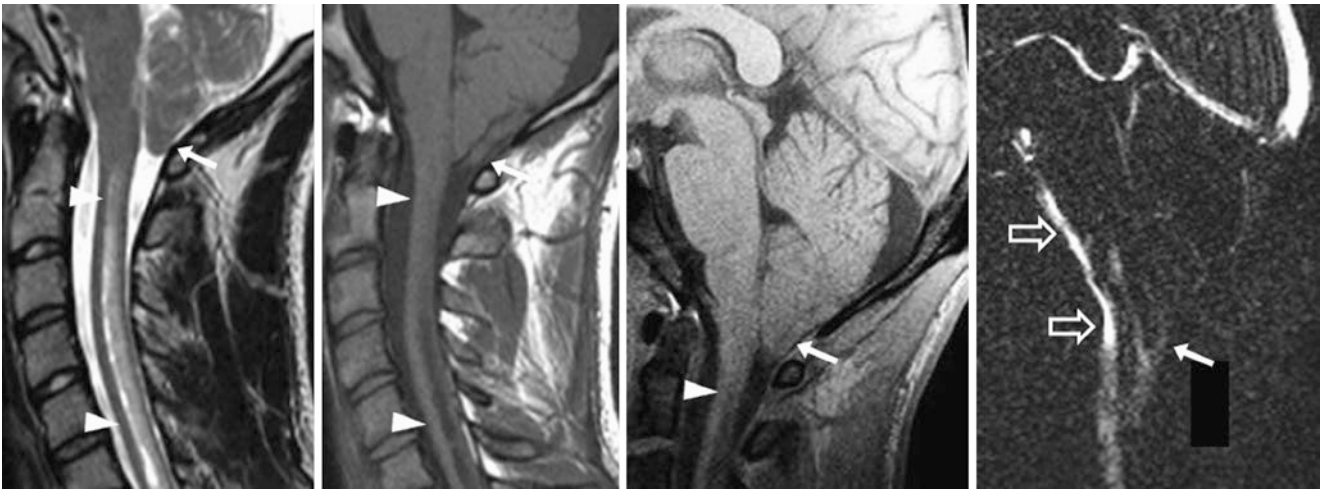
Comparison case of Chiari 1 malformation with syrinx. An 18-year-old patient with upper extremity symptoms and headaches had 10 mm of tonsillar ectopia/herniation (arrows) on a 1.5 T MRI with sagittal T2WI (left) and T1WI (left middle) as well as a syrinx
